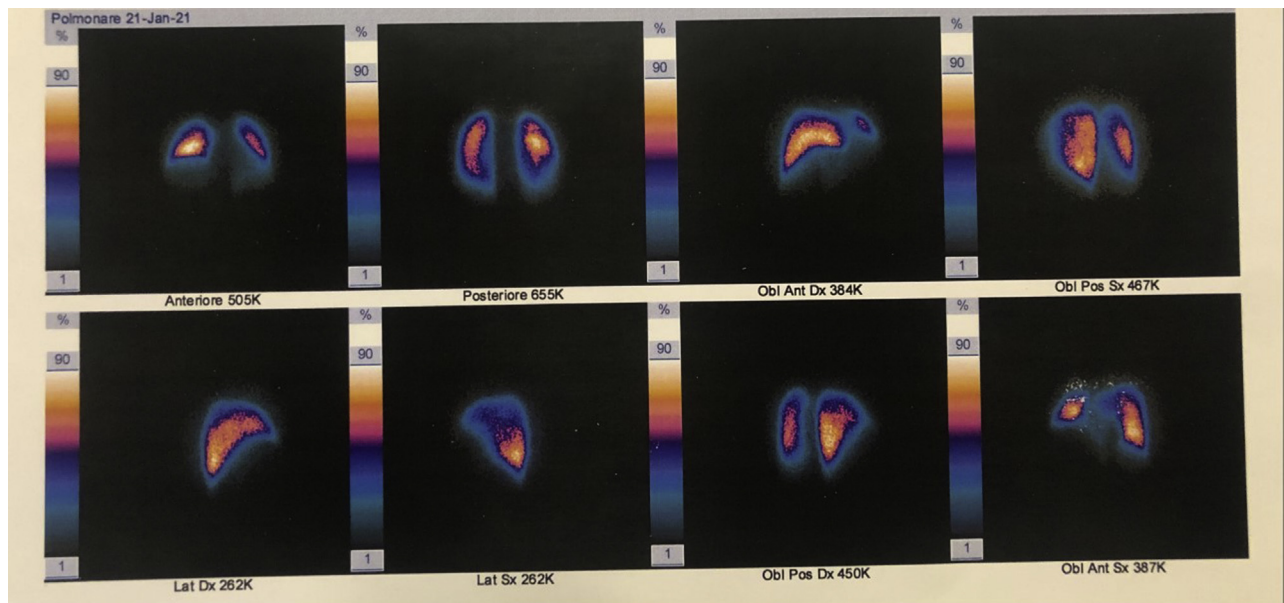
Preoperative computed tomography with ventilation/perfusion scintigraphy of patient number 1.
